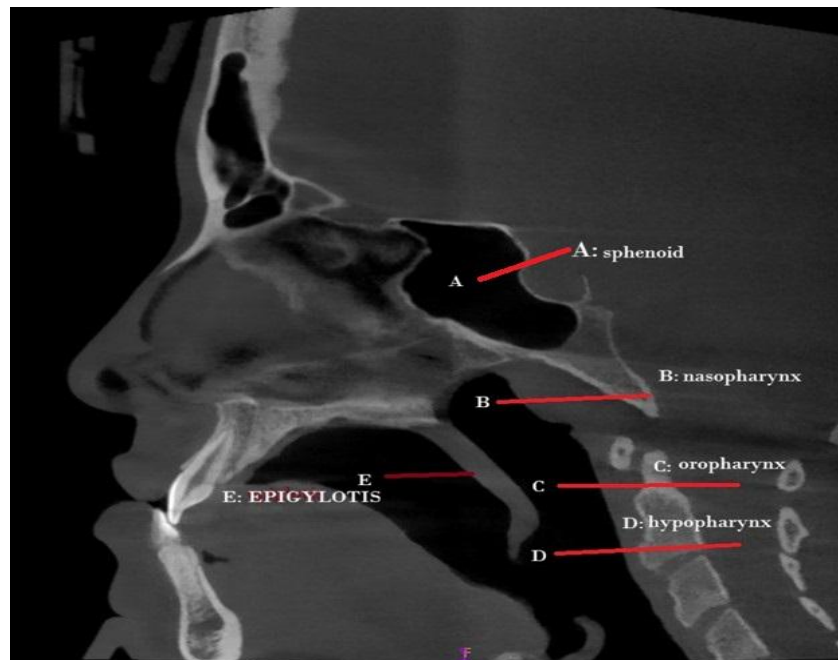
Three-dimensional cone beam computed tomography (CBCT) construction of a patient with a Class III skeletal relationship. The Class III profile typically features a retruded maxilla, which may impact airway patency. The anatomical landmarks used for airway volume measurement are identified as follows: point A represents the centre of the sphenoid (which is not included in the upper airway volume calculation), point B indicates the nasopharyngeal region, region C denotes the oropharyngeal area, region D identifies the hypopharyngeal region, and point E marks the epiglottis. All these identified points are utilized in the measurement of the total airway volume.
